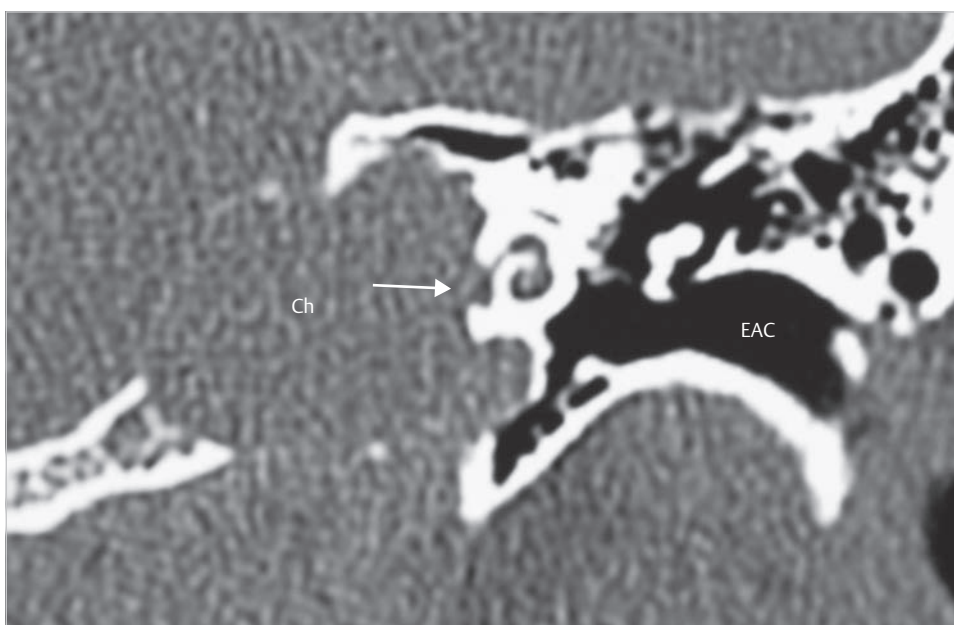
The coronal CT shows presence of a very large petrous apex lesion eroding cochlea (arrow), completely involving the inner ear. The tympanic cavity remains intact. Ch, cholesteatoma; EAC, external auditory canal.
